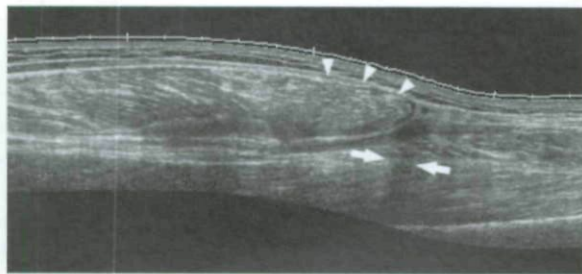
A 35-year-old rugby player with an acute complete rupture of the pectoralis major muscle at the musculotendinous junction while performing a bench press during training. (A) Longitudinal sonogram in the abducted and externally rotated position shows retracted pectoralis major (PM) sternal head fibers (arrows) with hypoechoic fluid in the muscle tendon gap. The medial head of biceps (B) is seen deep to the pectoralis major near its insertion. (B) Transverse sonogram of the pectoralis major sternal head tendon (asterisk) shows the medial extent of the injury to the musculotendinous junction. Fluid (arrows) lies adjacent to the forming tendon.
